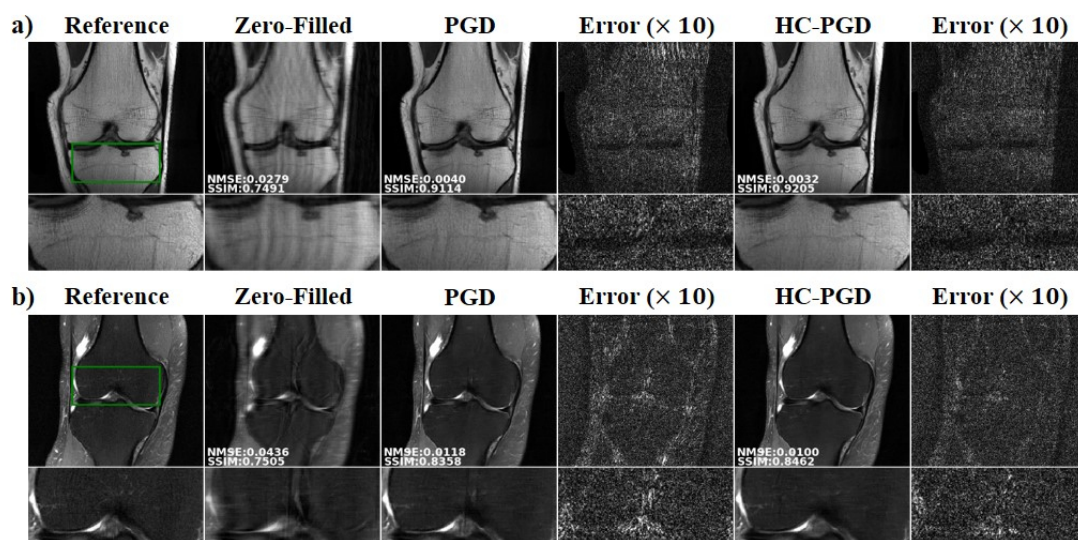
Results on random undersampling experiments from (a) the Coronal PD and (b) Coronal PD-FS datasets, at a 4-fold acceleration rate, reconstructed with DL-MRI reconstruction based on the conventional PGD and the proposed HC-PGD unrolling, as well as error images ($\times 10$), with the green rectangle showing the zoom-up area. Regardless of the undersampling pattern, the history-cognizant unrolling approach, HC-PGD suppresses the residual aliasing visible in the conventional PGD unrolling, as marked by the arrows. The quantitative metrics align with these observations.
